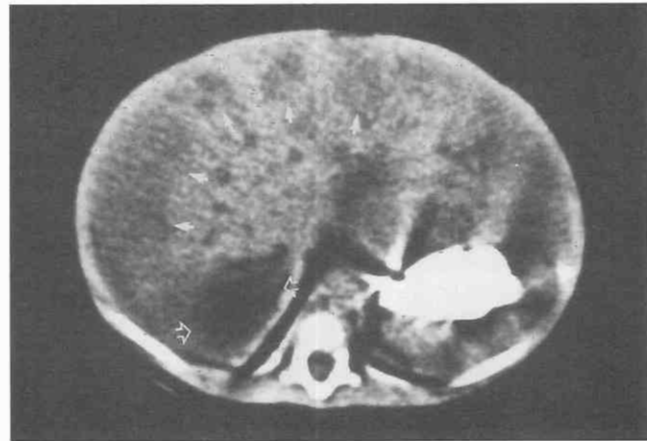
Hepatic metastases secondary to neuroblastoma. Contrast-enhanced CT shows numerous low-attenuation hepatic metastases (*arrows*) in a child with neuroblastoma (*open arrows*).
